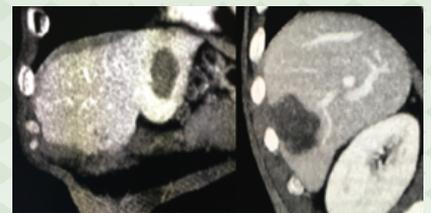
1 month follow-up CT scan
